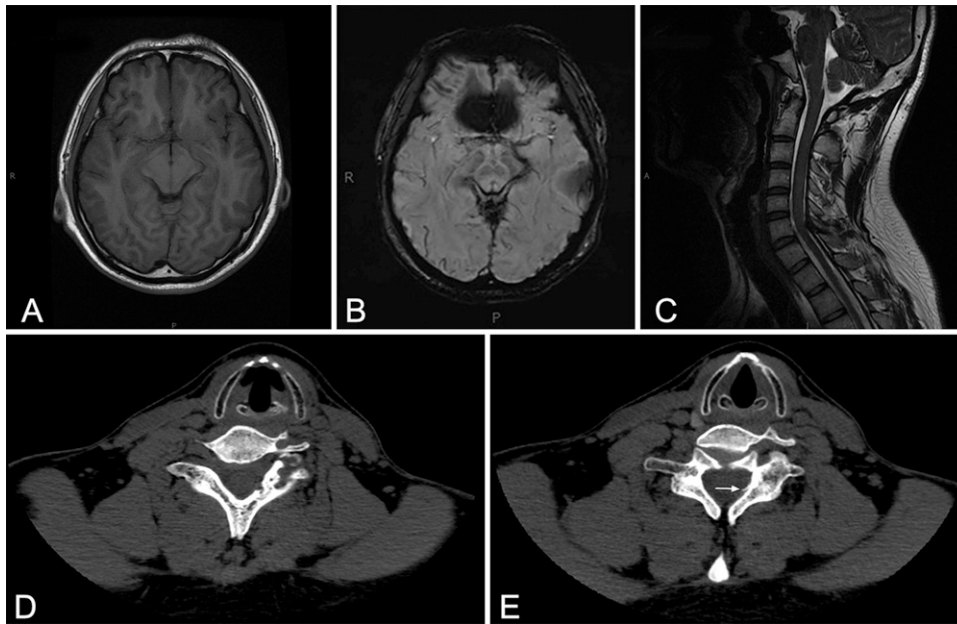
A and B: Axial T2-weighted and susceptibility-weighted brain MRI shows the characteristic hypointense rim along the dorsolateral pons. C: Sagittal T2-weighted cervical spine MRI shows a hypointense lesion in the C6–7 subdural and epidural space, indicating previous hemorrhage. D and E: CT of the cervical spine shows hyperosteoecy of the left C7 lamina, with a bone spur protruding into the spinal canal (*arrow*).
